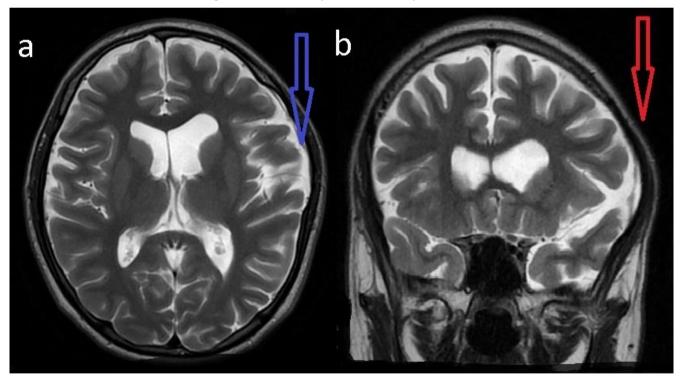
MRI examination 2 years later shows complete disappearance of the arachnoid cyst (blue arrow) (a). Cambering of the left temporal bone due to the arachnoid cyst (red arrow) (b).
